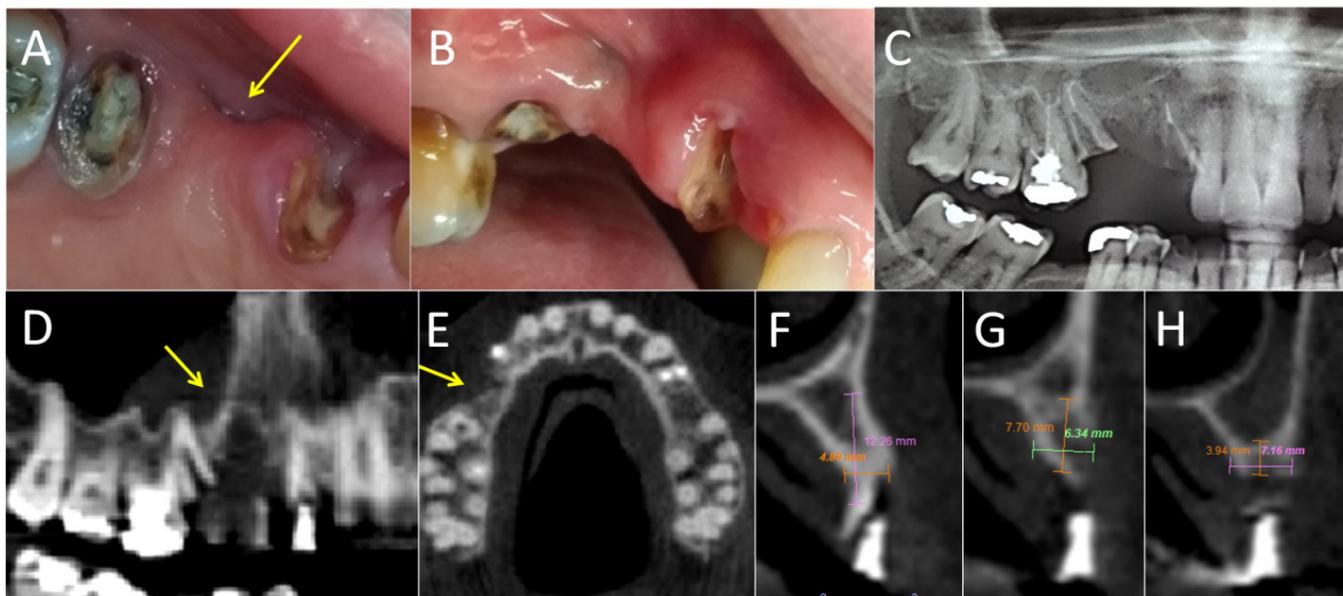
Clinical, radiographic and tomographic condition presented in the patient's clinical evaluation: coronaroot fracture in dental elements 13 and 15 associated with moderate resorption of the alveolar bone crest with marked retraction of the alveolar vestibular wall in element 15 (A, B and C). Panoramic (D) and axial (E) sections demonstrate severe cortical retraction. The cross-sectional view revealed moderate resorption of the alveolar bone crest in dental elements 13 (F), 14 (G) and 15 (H).
